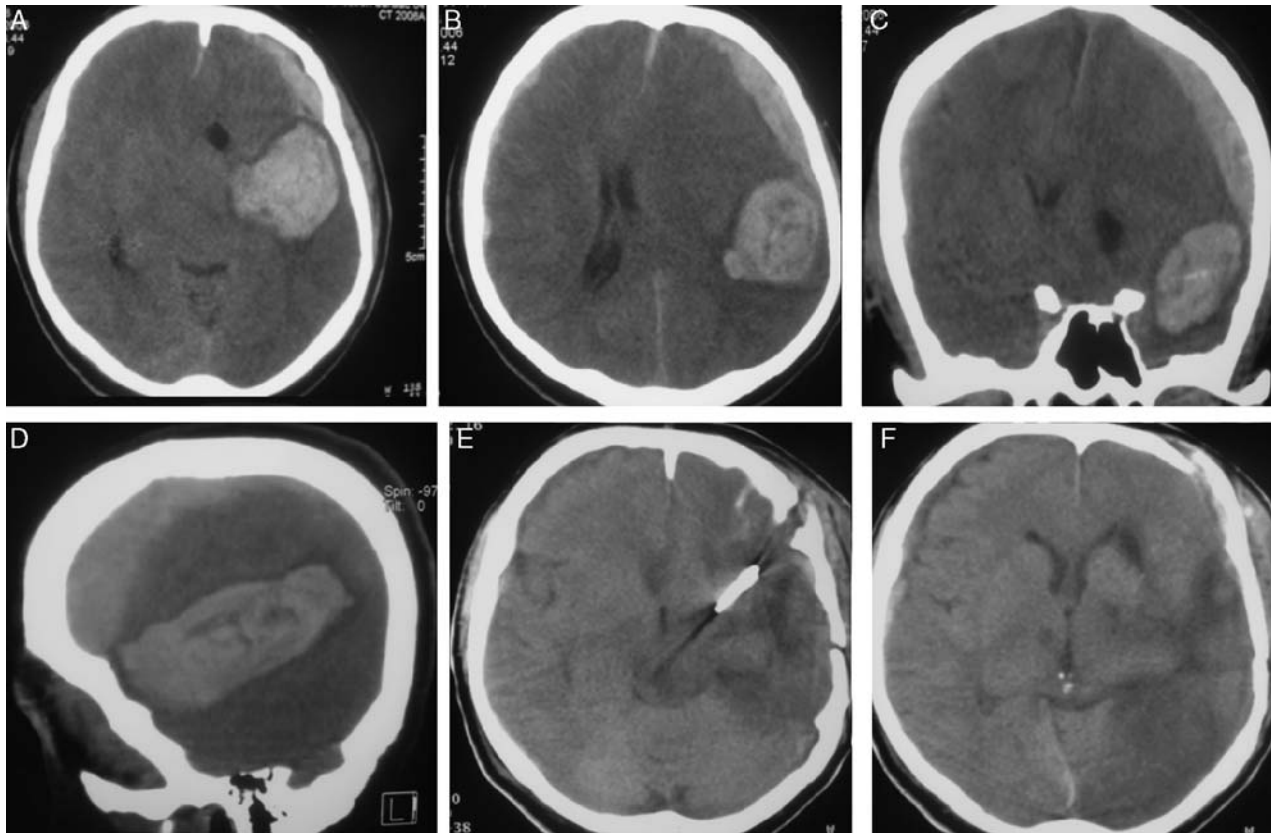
This 55-year-old man was transferred to our facility from an outside hospital. On admission, he had extensor posturing. A to D, Admission CT scan shows a large left temporal lobe intracerebral hematoma accompanied by an acute subdural hematoma. He was operated on promptly without angiography where a ruptured left middle cerebral artery bifurcation aneurysm was found. E and F, Postoperative CT scan shows complete evacuation of the clot. CT indicates computed tomography.
